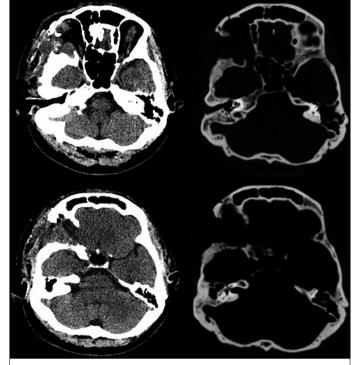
Simple multiplanar CT and post-surgical bone window, where craniectomy locations are observed in the frontotemporal sphenoidal region after an almost full resection of the lesion.
